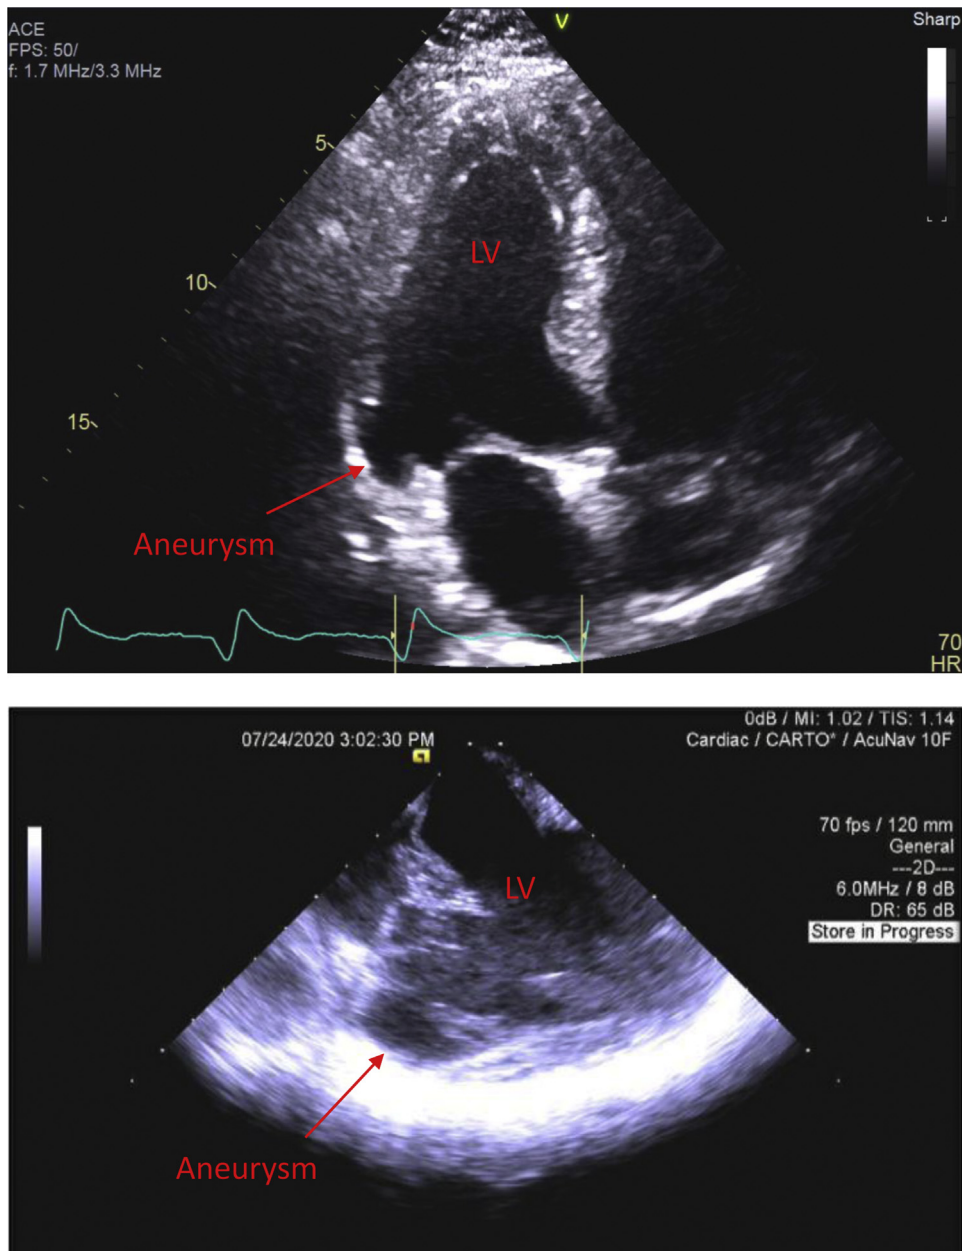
A: Transthoracic echocardiogram, apical 4-chamber view (Mayo orientation): mitral apparatus and submitral aneurysm. B: Intracardiac echocardiogram: left ventricle (LV), mitral apparatus, and submitral aneurysm.
